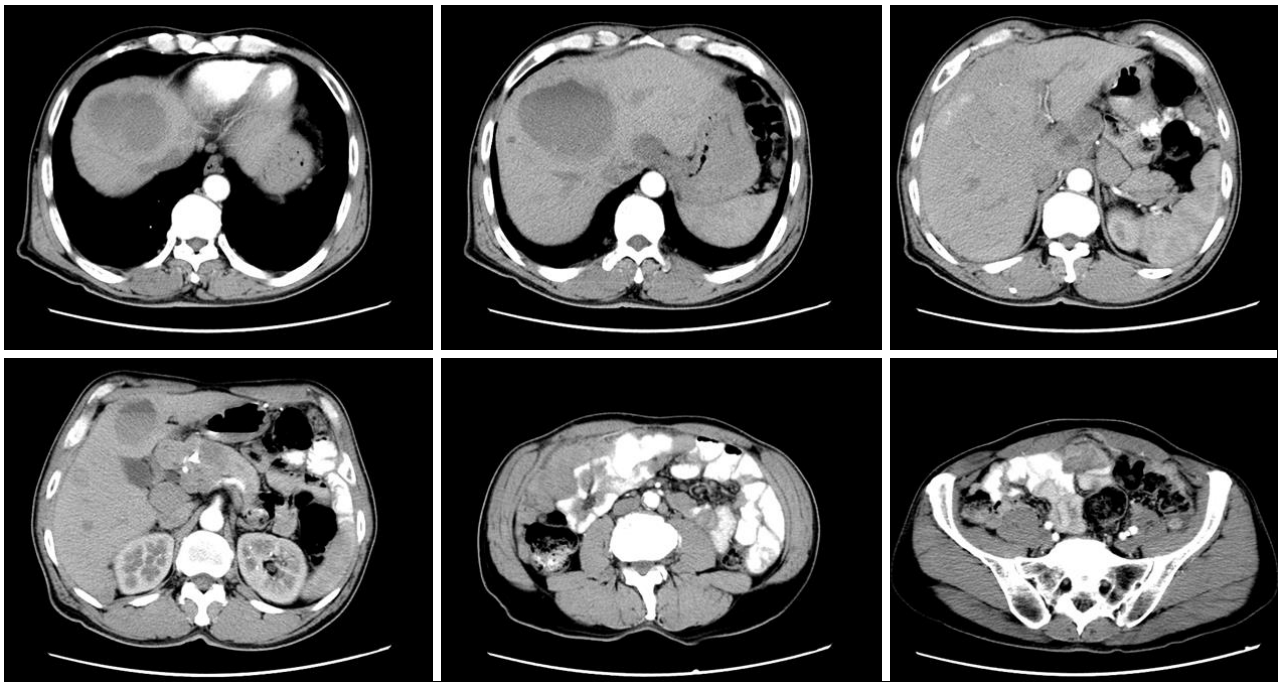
Abdominal and pelvic CT (May 2, 2013).
